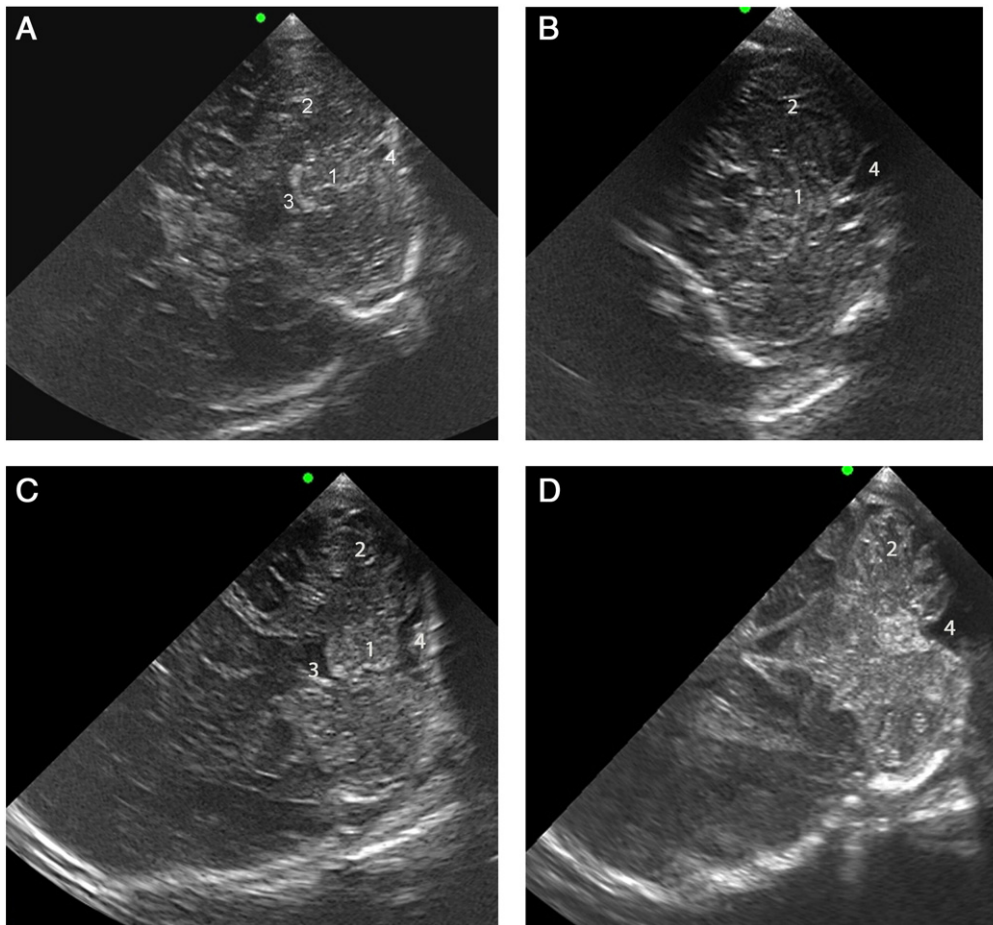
Normal ultrasound scan in full-term neonate using the MF as acoustic window. A and B: Axial views, with A middle and B inferior view. C and D: Coronal views with C middle and D posterior–inferior view. Vermis (1), cerebellar hemisphere (the hemisphere located closest to the transducer is visualized in the upper part of the image) (2), 4th ventricle (3), cisterna magna (4). Note the subtle differences in echogenicity and anatomical details between the two hemispheres, due to differences in distance from the transducer.
